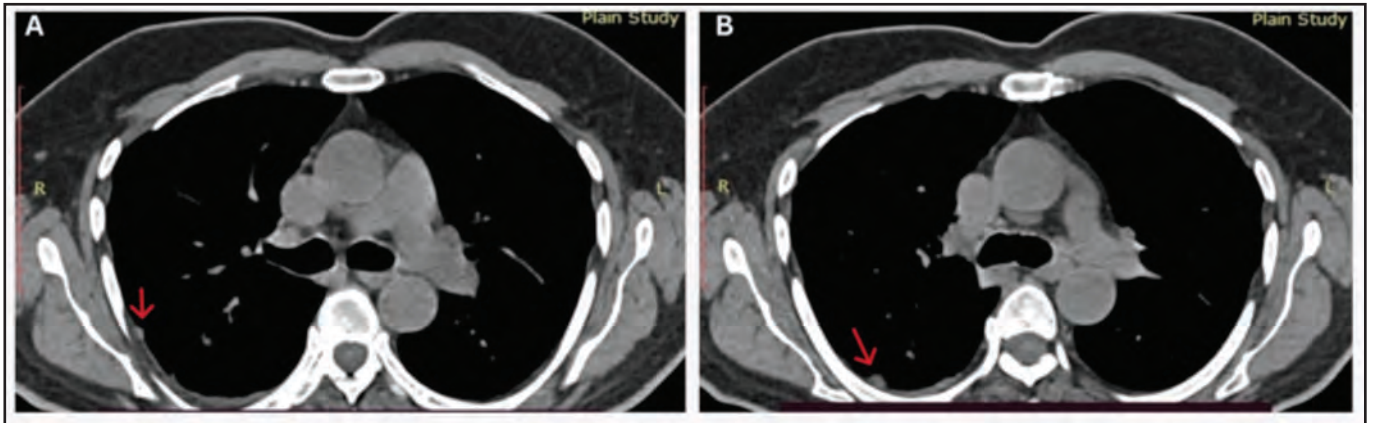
Computed tomography showing multiple pleural nodules (arrow) without evidence of lesions in the lungs.
